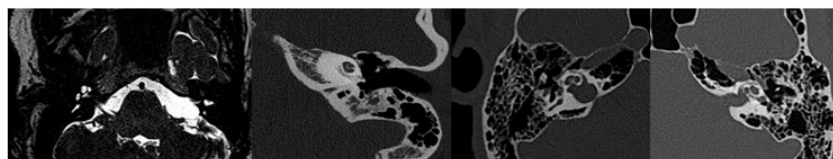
Axial FIESTA MR image through the left internal auditory canal in a patient with hearing loss demonstrates labyrinthitis ossificans. There is loss of the normal fluid signal in the middle and apical cochlear turns (arrowhead), consistent with the fibrotic phase of the disease.
